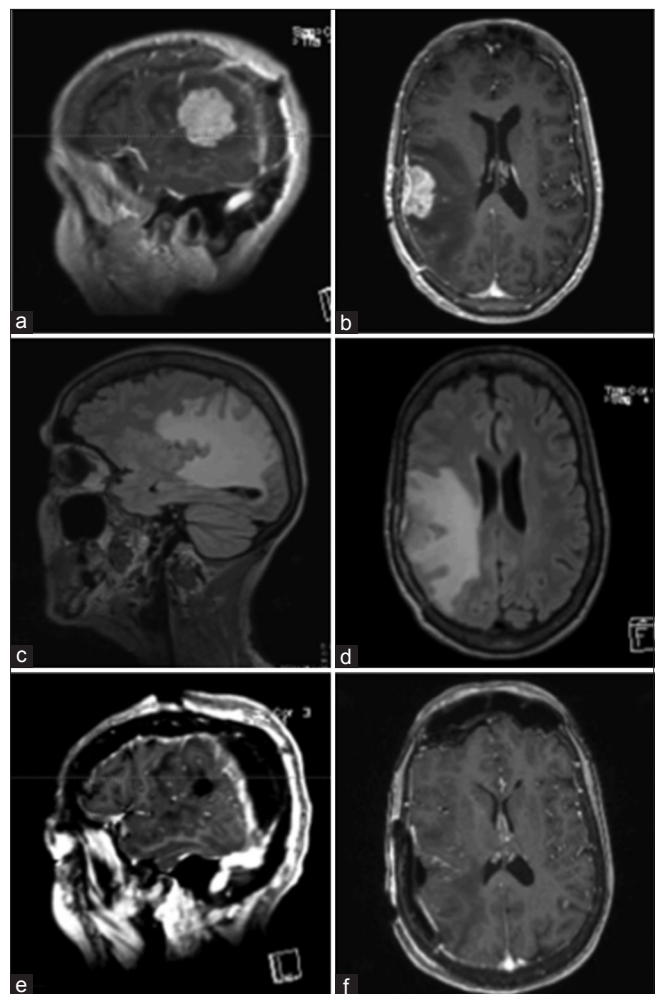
Pre-operative MRI of brain, showing a new enhancing dural based lesion anterior to the prior resection cavity (a-d). Immediate post-operative MRI of brain, demonstrating gross total resection of the lesion (e and f)
